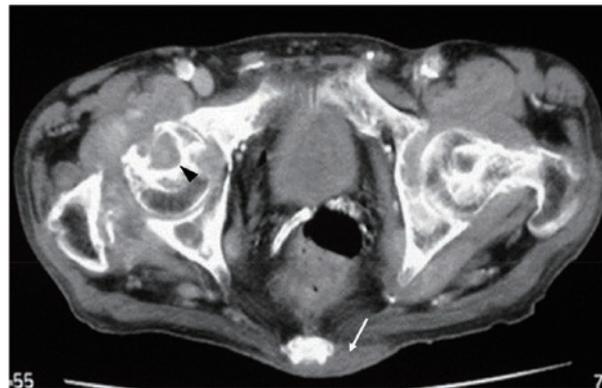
Contrast-enhanced CT at the level of the femoral heads
